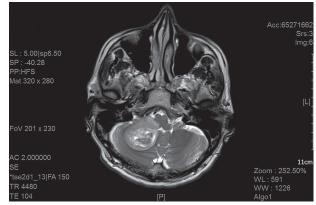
MRI of head before treatment - transversal
